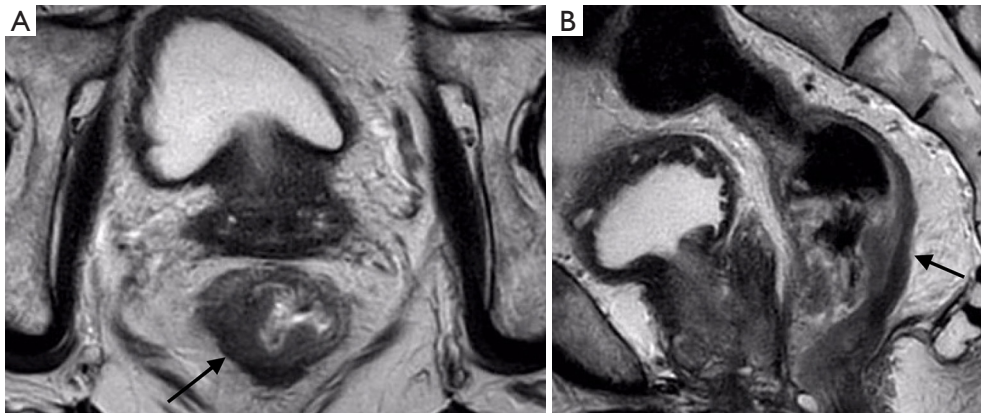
Rectal MRI in the (A) axial and (B) sagittal planes shows tumour extension into the muscularis propria without definite extramural spread (mrT2 tumour). This tumour is amenable to primary resection.
